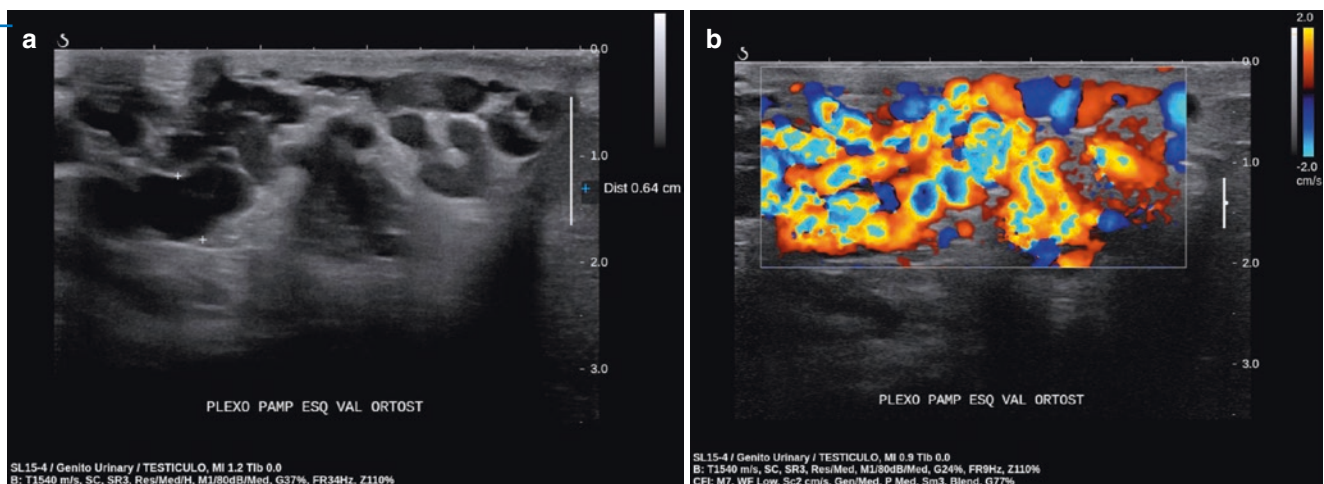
Varicocele Grade 4. (a) B mode ultrasound shows enlarged veins in the upper pole and in front of the testicle even in the supine position. (b) Color Doppler shows reflux in the pampiniform vein during Valsalva
